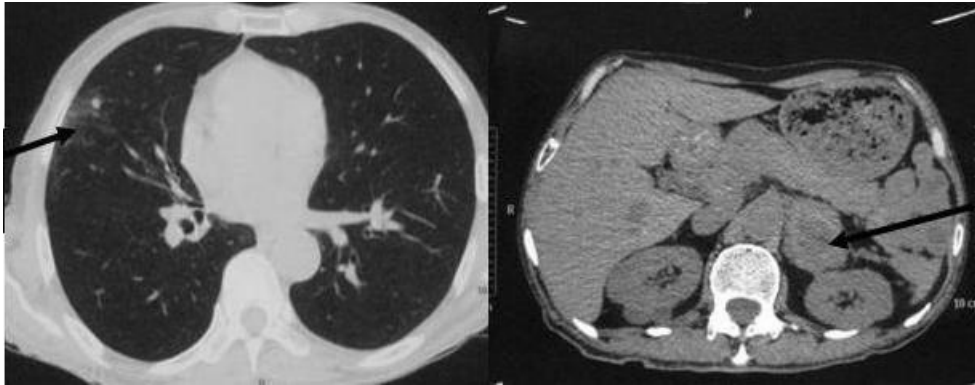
Follow up CT Thorax with Abdomen showing resolution of adrenal mass and infiltrations in right lung.
